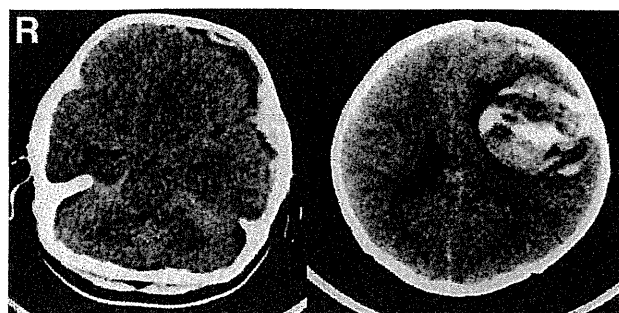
Case 2. Preoperative computed tomography scans showing left frontal intracerebral hemorrhage with subdural hematoma.
